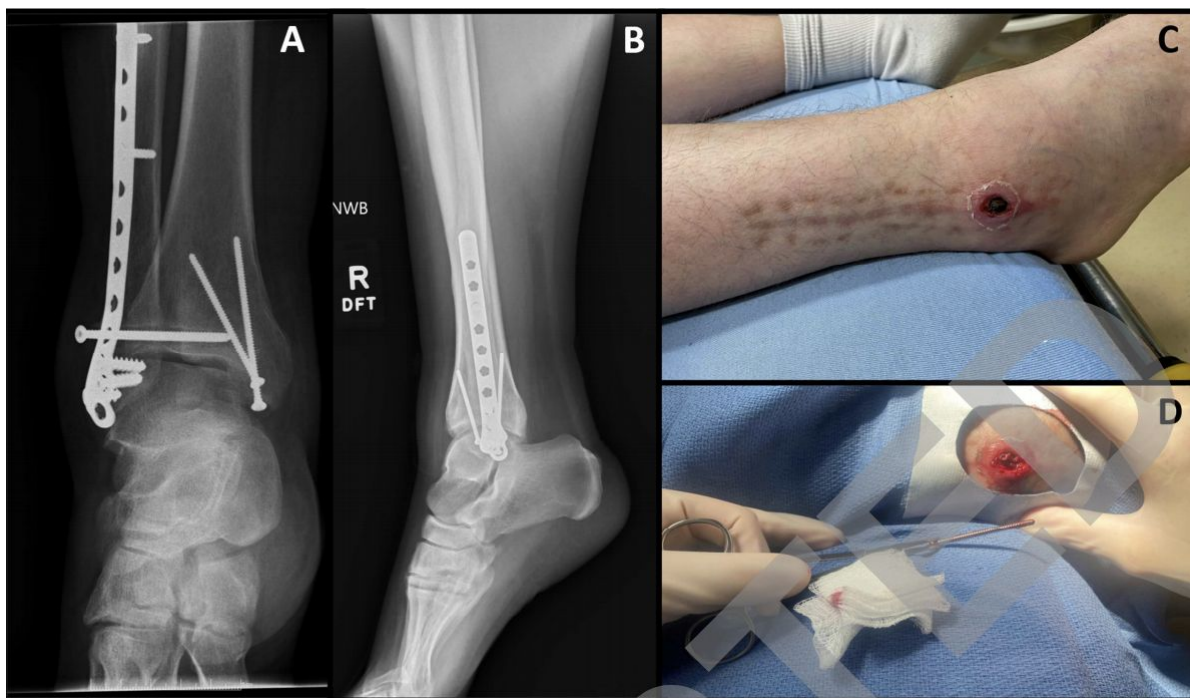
AP (A) and lateral (B) radiographs are shown of the healed ankle fracture and it is clearly evident that the syndesmotomic screw has backed out (A). A clinical photo upon presentation is shown, where the head of the syndesmotomic screw is visible within the wound (C). The screw is shown following removal in the emergency department (D) prior to wound closure with absorbable sutures and placement of a soft dressing to minimize the need for an in-person immediate post-operative follow-up visit during the COVID pandemic.
